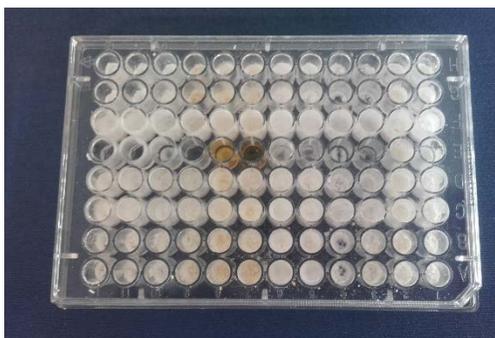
96-well plate after the cocrystallization by ultrasound assisted.
